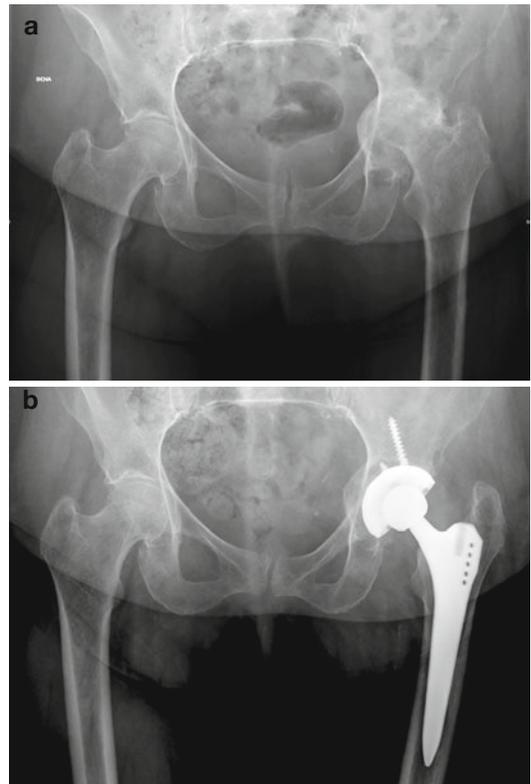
(a) Preoperative radiograph of a female patient of 76 years old. (b) Postoperative radiograph with a grit-blasted hemispherical cup and autograft from the femoral head and a second-generation Zweymüller stem at 2 years
